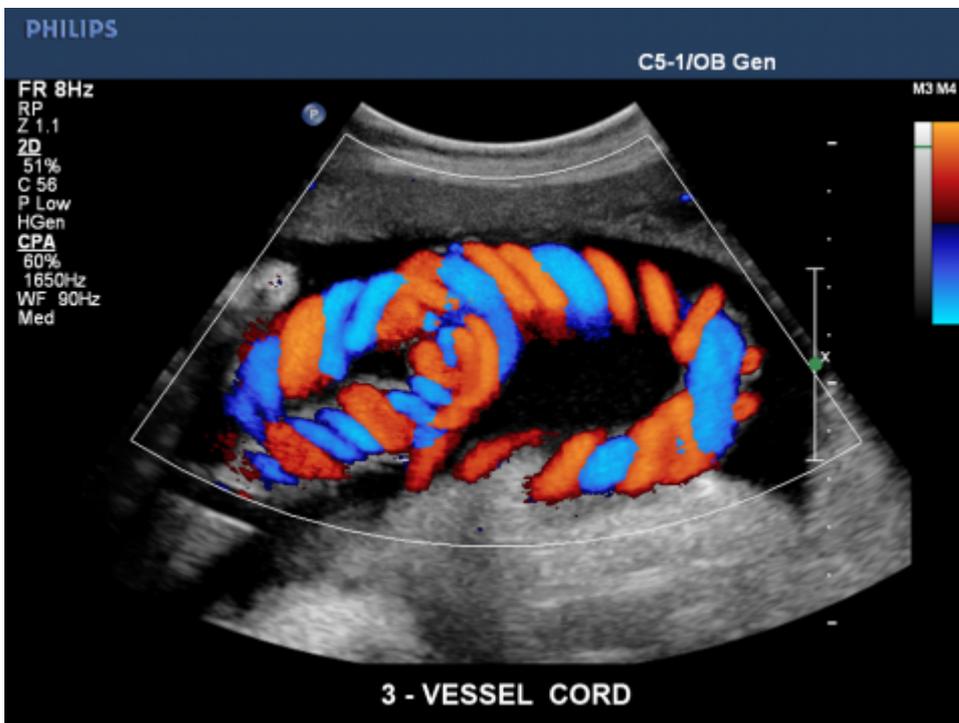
Color Doppler of three-vessel cord.
